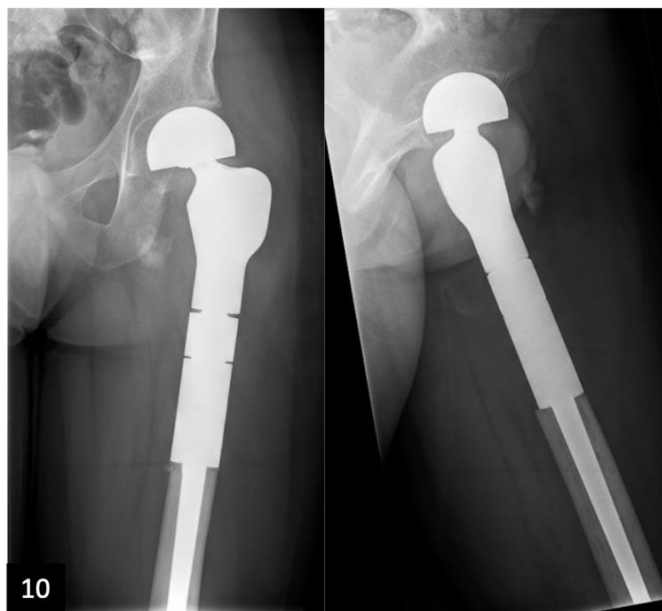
Postoperative pelvis x-ray. Replacement of the proximal femur with a megaprosthesis.
